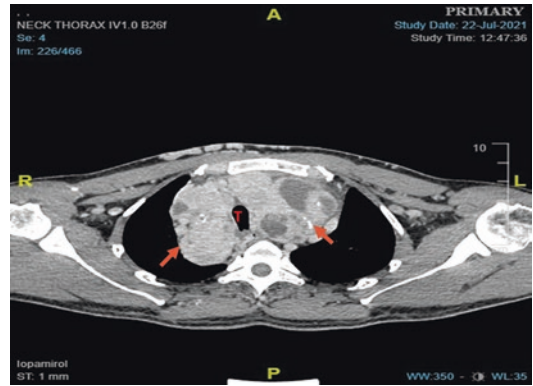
CT scan of the thorax showing a massive retrosternal thyroid which is heterogenous (arrows). The mass has caused narrowing of the trachea (T)
